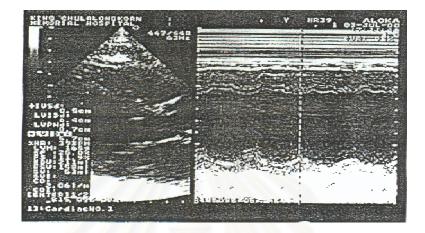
The echocardiographic views of M-mode for LVEF measurement
